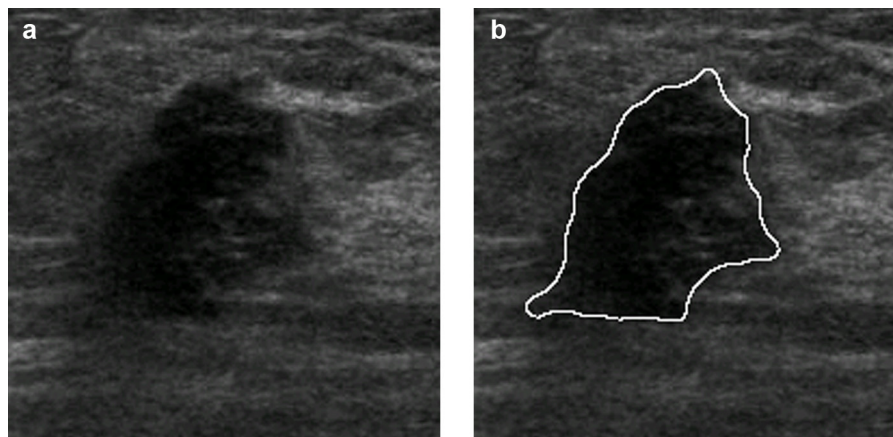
An example of a malignant tumor classified correctly by both the proposed CAD algorithm and the conventional CAD method. Among six predicted BI-RADS findings of this tumor, there were four malignant findings: irregular, not parallel, spiculated, and hypoechoic. The malignancy score of this tumor is 0.8 in the diagnostic algorithm. (a) The original sonographic image and (b) The contour was outlined for feature extraction.
